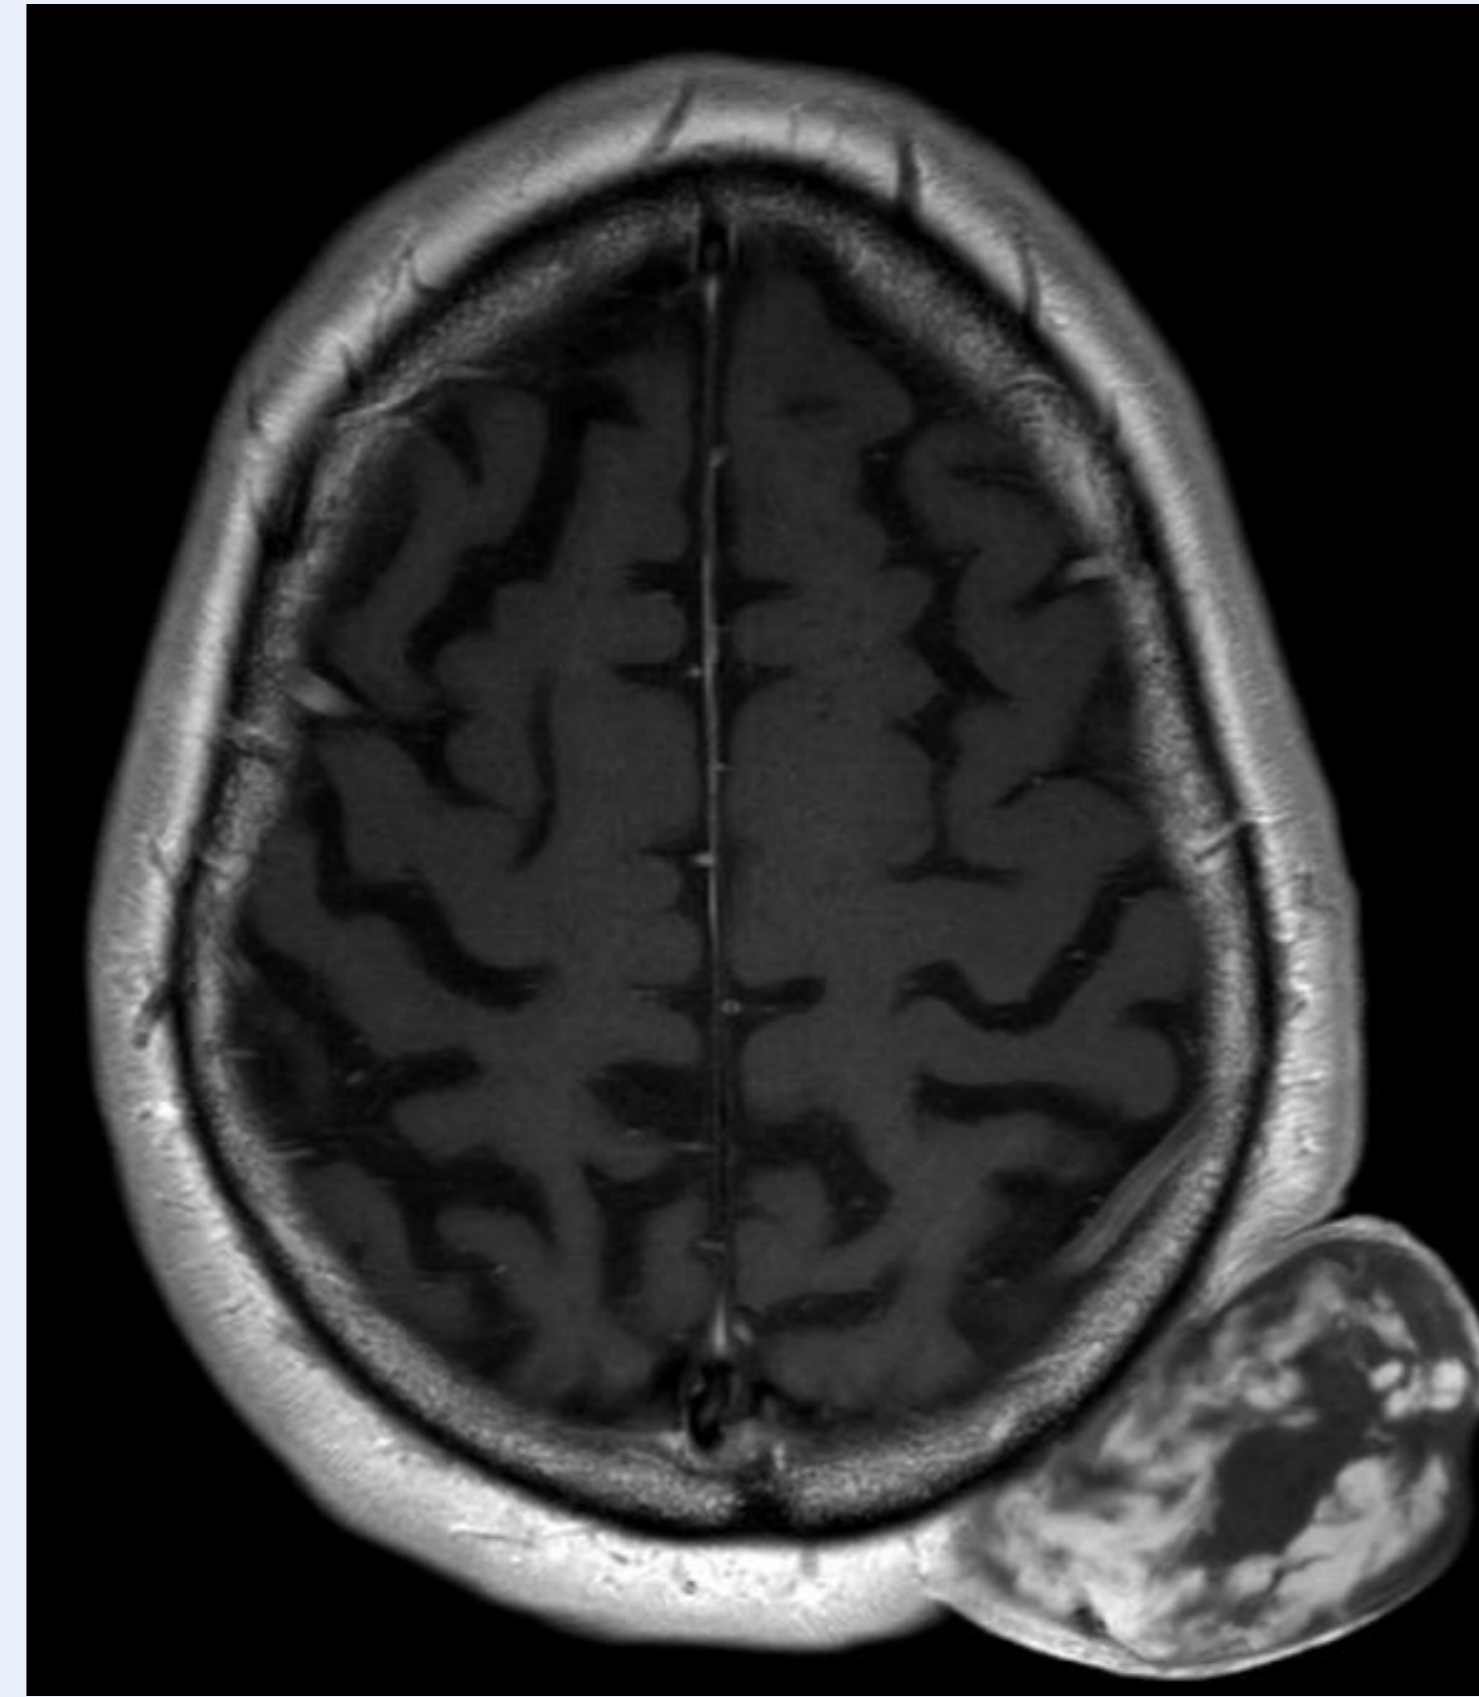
Preoperative MRI and CT showing a well-delineated subcutaneous mass with contrast enhancement on MRI and focal calcifications (blue arrow).
